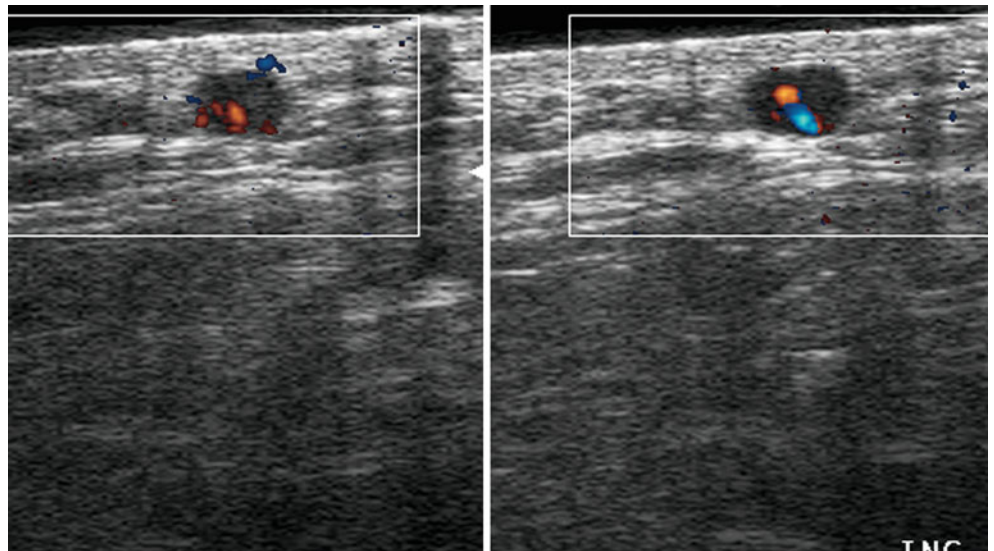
In-transit metastasis. Directional power Doppler image. Melanoma nodule of the leg (arrows) is seen compressing the internal saphenous vein
